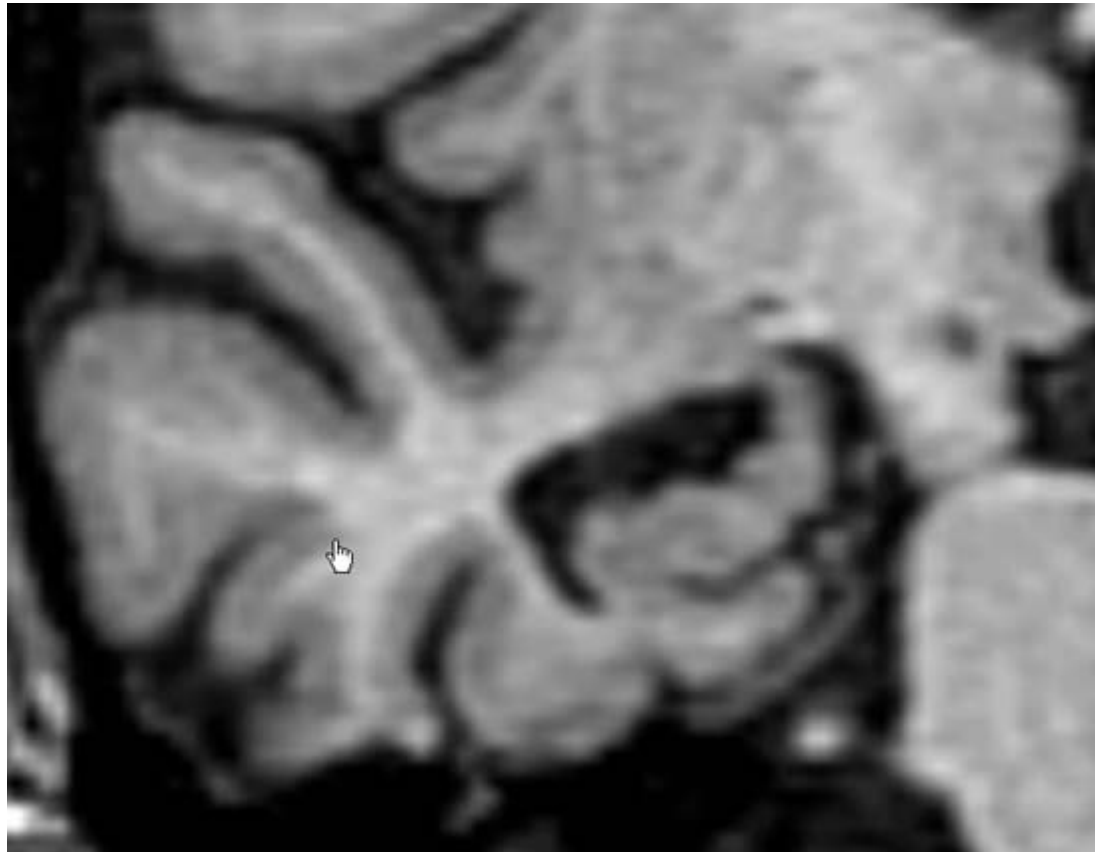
Comparable T1-weighted coronal MRI slices perpendicular to the long axis of the hippocampus showing a normal-sized hippocampus in a control person (total hippocampal volume uncorrected for head size 3,480 mm³ right and 3,164 mm³ left) and a smaller hippocampus in an MCI patient (total hippocampal volume uncorrected for head size 2,050 mm³ right and 2,580 mm³ left). Images courtesy of L. van der Pol, Alzheimer Center and Image Analysis Center, Vrije Universiteit Medical Center, Amsterdam, The Netherlands.
